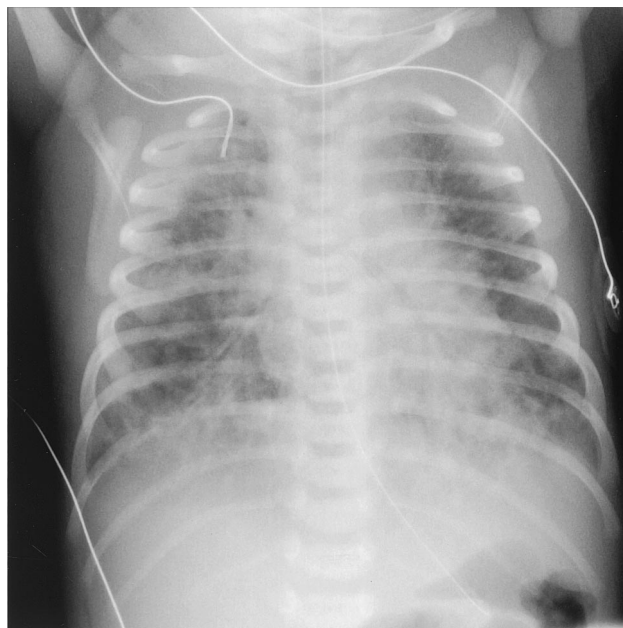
Case 1, Frontal chest radiograph demonstrates severe pulmonary edema in this neonate delivered in water bath.
